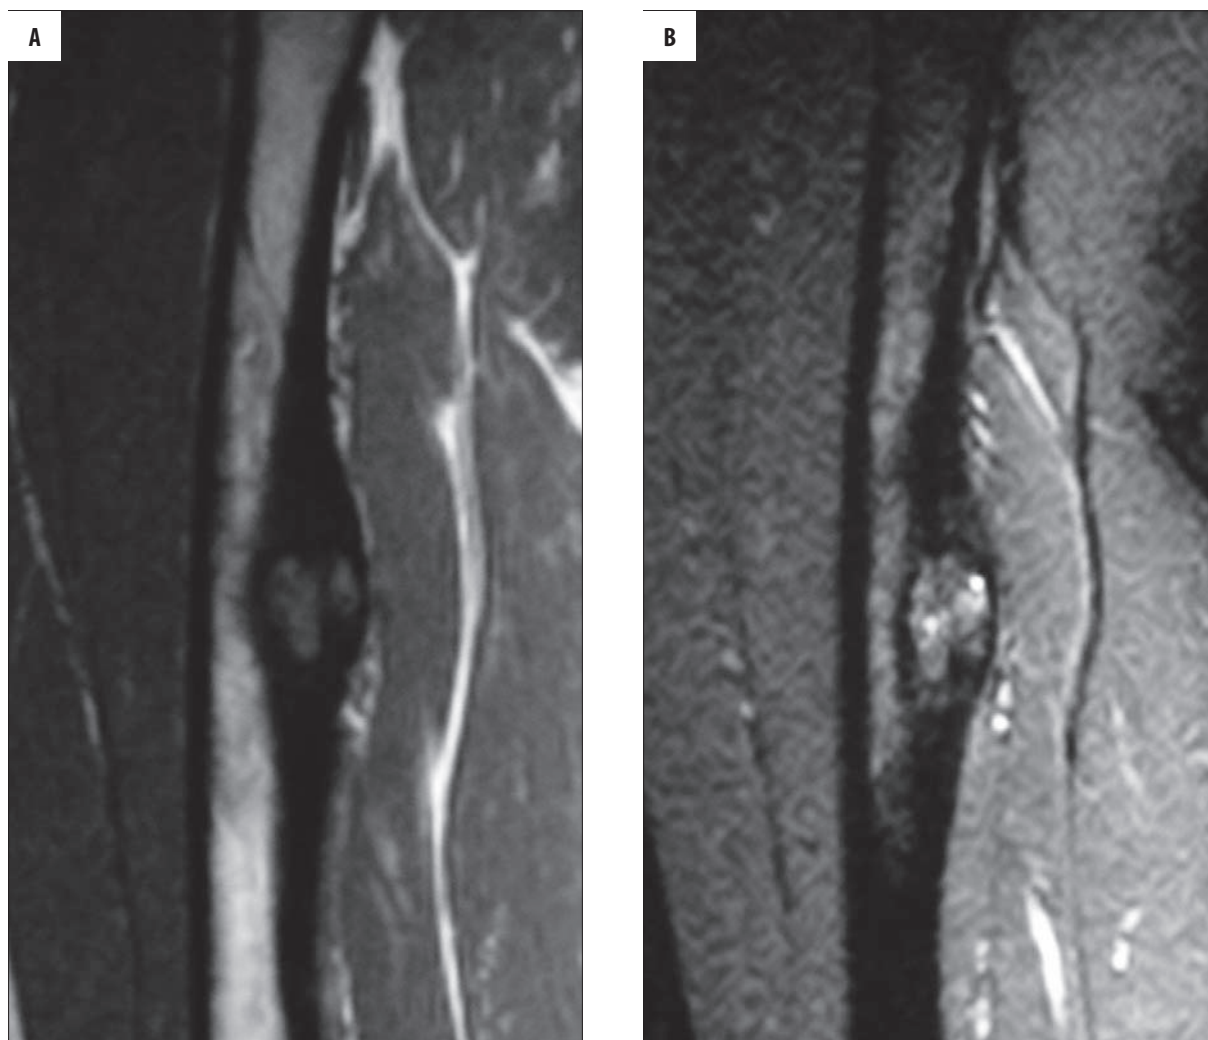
MRI shows a lesion of intermediate signal intensity on T1-weighted images (A) and intermediate to high signal on T2-weighted images (B) with signal voids consistent with calcifications. T2-weighted fat saturated images reveal accompanying bone marrow edema (arrows) (B).
